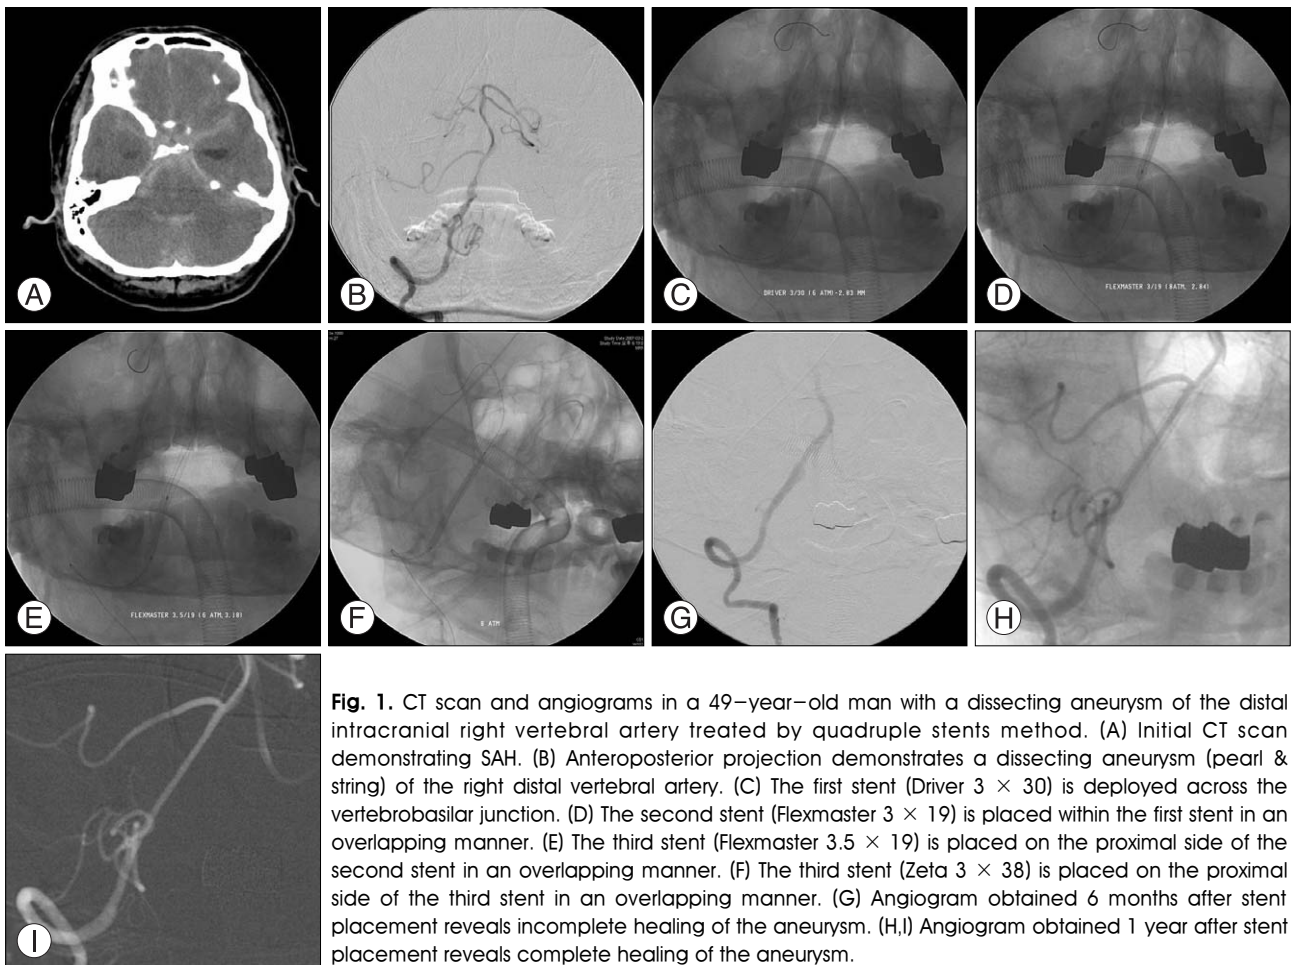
CT scan and angiograms in a 49-year-old man with a dissecting aneurysm of the distal intracranial right vertebral artery treated by quadruple stents method. (A) Initial CT scan demonstrating SAH. (B) Anteroposterior projection demonstrates a dissecting aneurysm (pearl & string) of the right distal vertebral artery. (C) The first stent (Driver 3 × 30) is deployed across the vertebrobasilar junction. (D) The second stent (Flexmaster 3 × 19) is placed within the first stent in an overlapping manner. (E) The third stent (Flexmaster 3.5 × 19) is placed on the proximal side of the second stent in an overlapping manner. (F) The fourth stent (Zeta 3 × 38) is placed on the proximal side of the third stent in an overlapping manner. (G) Angiogram obtained 6 months after stent placement reveals incomplete healing of the aneurysm. (H,I) Angiogram obtained 1 year after stent placement reveals complete healing of the aneurysm.
